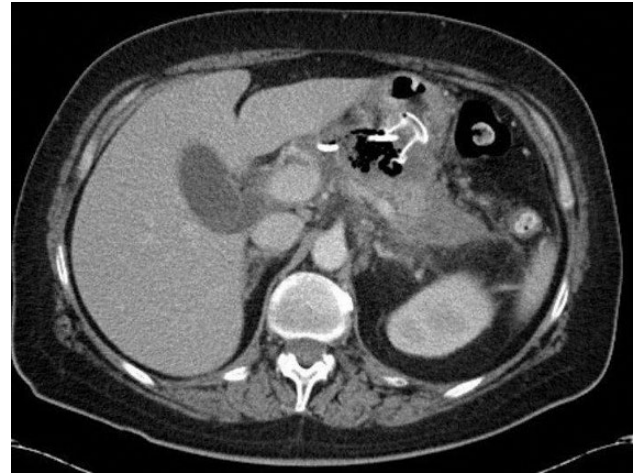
CT scan from the patient shown in Figs 30.1 and 30.2 shows the expandable stent in place and near resolution of necrotic cavity.
